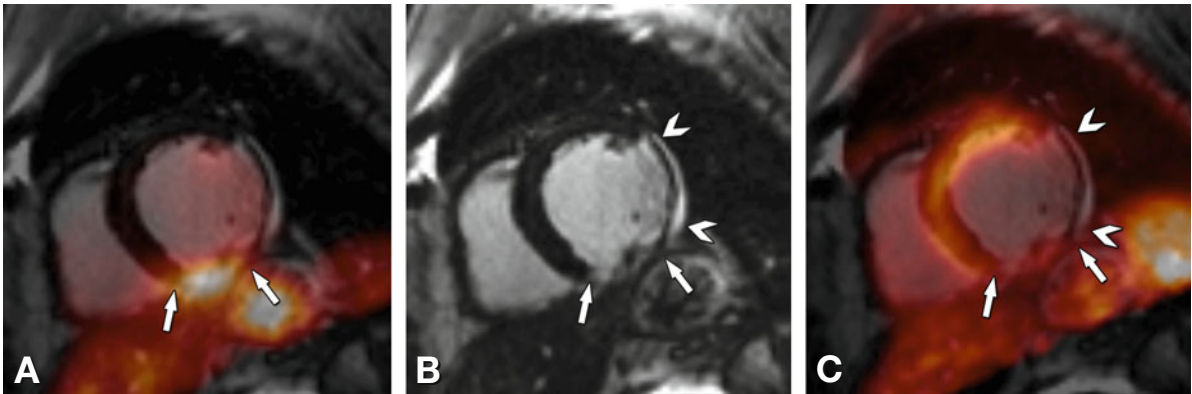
Patient with an acute myocardial infarction after successful revascularization of the right coronary artery undergoing integrated PET/MRI. Fasting ^{18}F FDG PET shows focal accumulation in the inferior wall (arrow in Panel A) with matching diffuse late enhancement on MRI (arrow in Panel B) and severely reduced PET perfusion (arrow in Panel C). In addition, there is a chronic infarct of the lateral wall seen by thinning of the myocardium and late enhancement on MRI (arrowhead in Panel B) with corresponding absent perfusion on ^{13}N $_3$ PET (arrowhead in Panel C). Although the diagnostic and prognostic impact of hybrid PET/MRI needs to be defined in larger cohorts, this example demonstrates its clinical feasibility (Courtesy of S. Nekolla and C. Rischpler, Munich)
